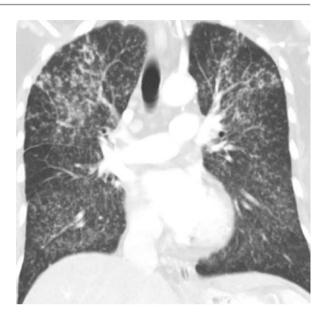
HRCT of the lungs, coronal reconstruction: multiple nodular patterns in the perilymphatic distribution (nodules in the central part of secondary pulmonary lobules and multiple nodules on the interlobular fissure, and in the subpleural areas, arranged in clusters)
